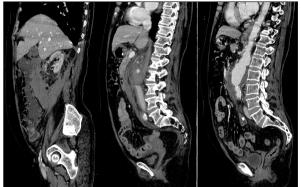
(a,b,c) Sagittal CT abdomen sections showing craniocaudal and anteroposterior extent of thrombus in infrarenal abdominal aorta with hyperdense fluid collection seen in retroperitoneum on right side—s/o contained rupture
